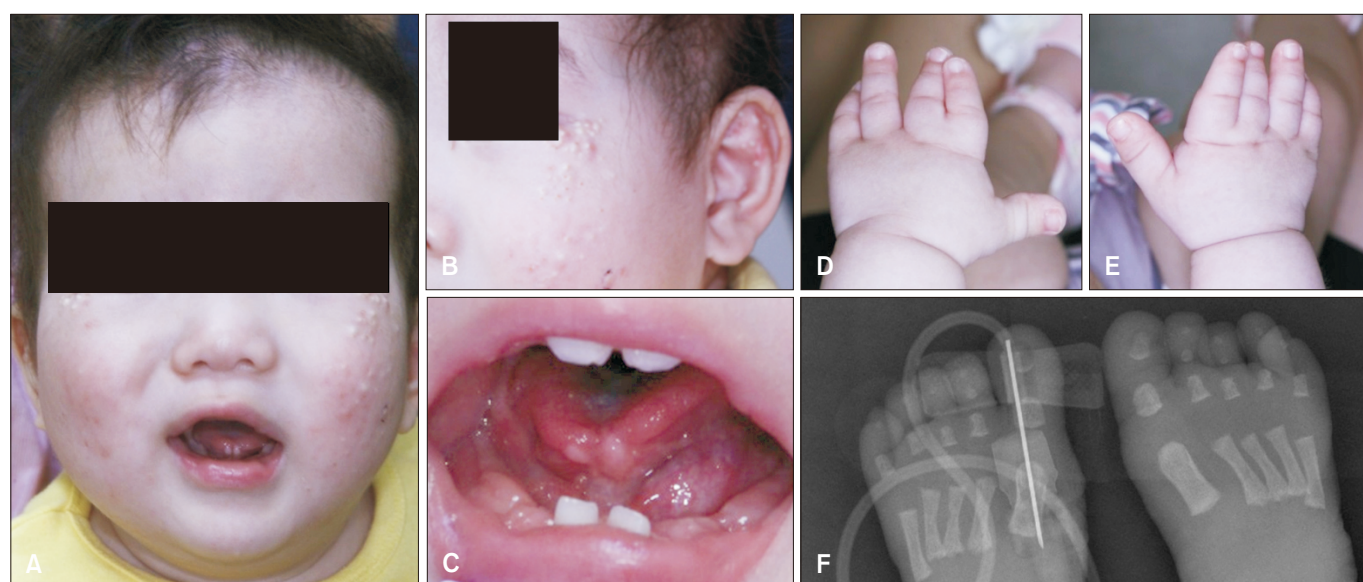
(A) Presense of multiple milia on both cheek, predominantly on the left side. (B) Presence of multiple milia in the cheek as well as auricle. Partial hypotrichosis was also noted. (C) Shows bifid tongue and short frenulum. (D, E) Clino-brachy-syndactyly of hand were presented. (F) Anomalous deformities of both toes were seen on X-ray.
